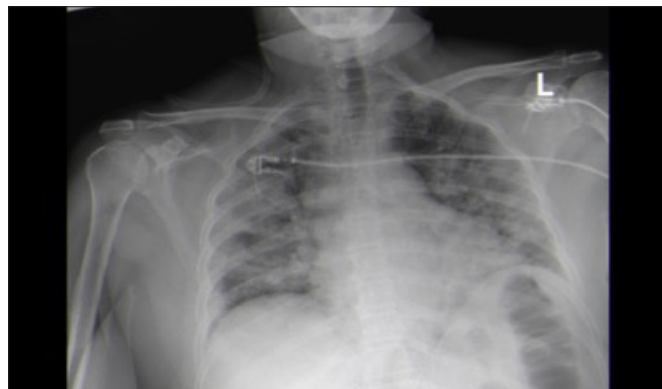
Chest X-ray of case 2. Chest X-ray showing diffuse shadowing bilaterally in case 2.
